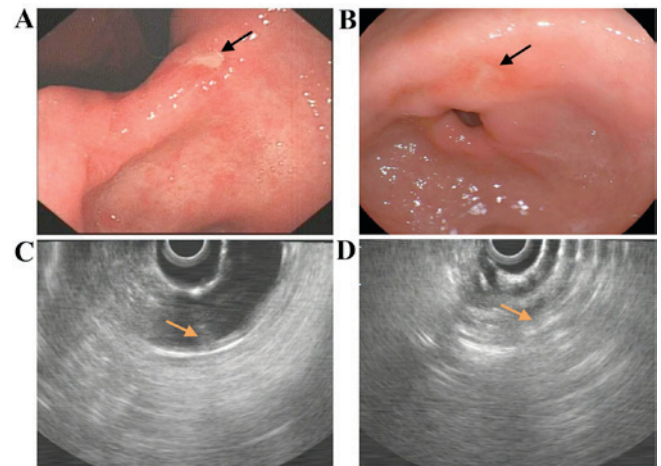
Gastroscopy and endoscopic ultrasonography on days 7 and 28 post-IRE. Gastroscopy indicated an (A) oval ulcer (black arrow) with whitish fur and surrounding congestion and edema on day 7 post-IRE; (B) this ulcer (black arrow) became shallower and smaller with less congestion and edema on day 28. Fusion of the stomach layers (yellow arrows) in the ablated areas on days (C) 7 and (D) 12 post-IRE, as indicated by endoscopic ultrasonography. IRE, irreversible electroporation.
